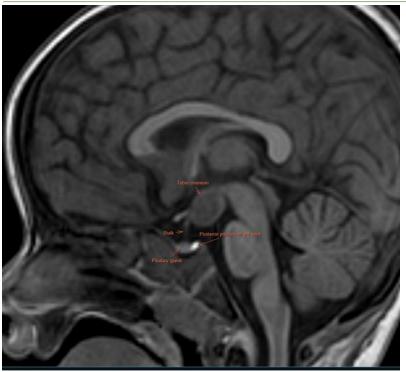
T1 MRI showing suprasellar hypothalamic hamartoma (isointense lesion) with anatomical parts labelled in the sella region and hypothalamus.
